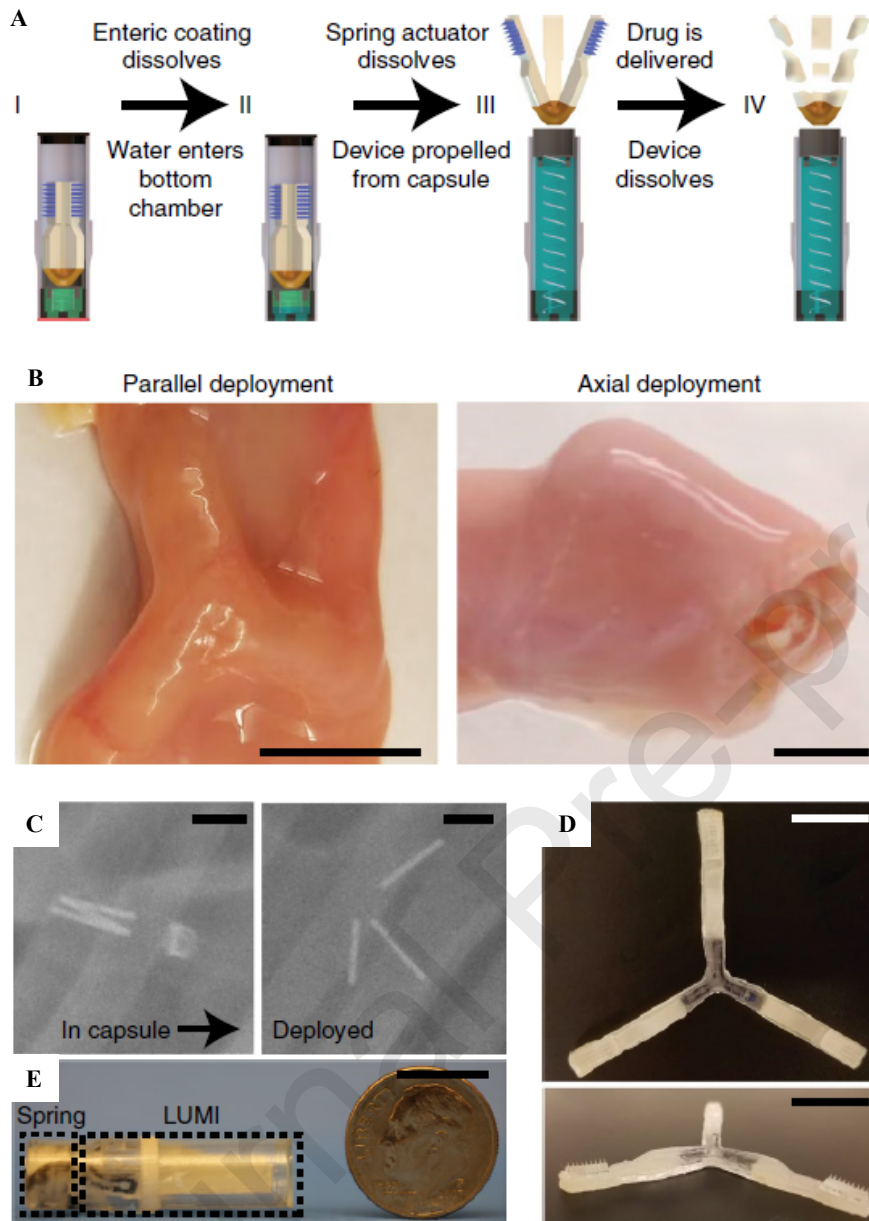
Design and specification of the luminal unfolding MN array injector. (A) Actuation scheme of the device; (B) Multiple orientations of the dispositive in the duodenum, (left) parallel and (right) axial; (C) Radiographic images revealing the actuation of the capsule *in vivo* within two hours; (D) Images of the unfolded device observed from the top and side and (E) Unfolding dispositive inside the capsule. (Reproduced with permission from [188]).
